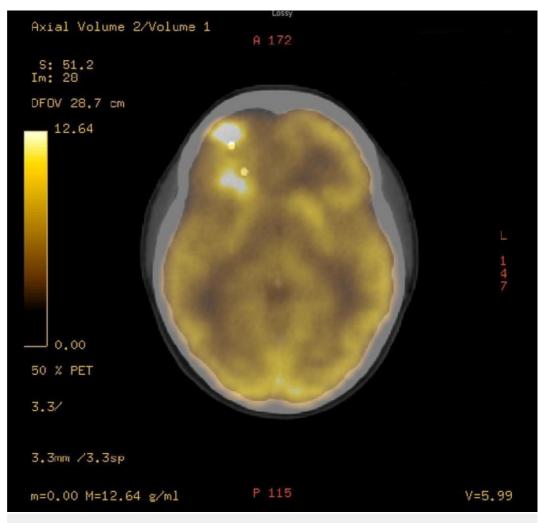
FDG-PET showing increased radioisotope uptake in the areas of contrast enhancement on MRI
